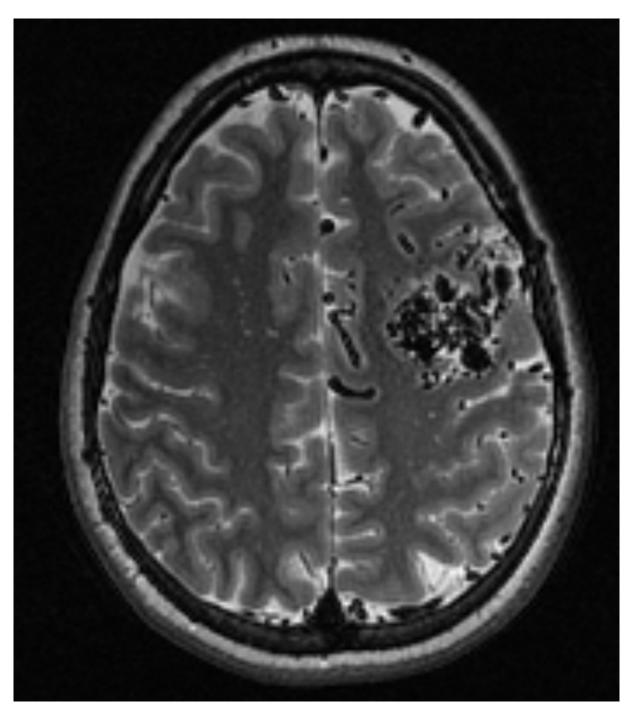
T2-weighted axial MR scan of left frontal AVM SM III.
